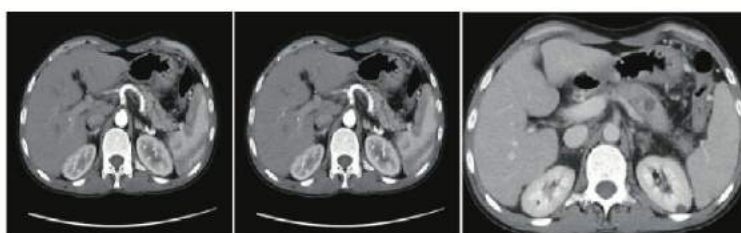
Axial CT image reveals changes of pancreatitis as evidenced by the presence of peripancreatic fluid and inflammatory changes and cystic changes within the body of pancreas
